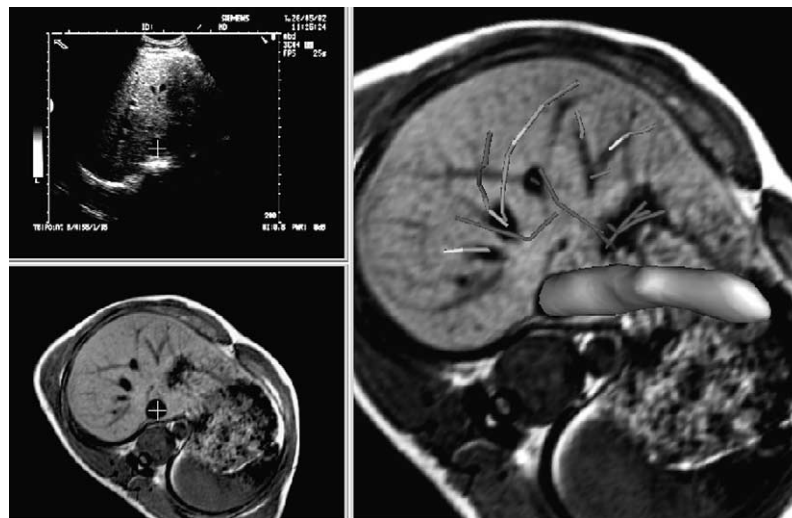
Graphical user interface used to pick points and lines to calculate “bronze standard” transformation. Top left shows an ultrasound slice in which vessel points are picked, bottom left shows the current best estimate for the corresponding slice through the MR volume. Right shows the 3D image features which have already been picked and the current best estimate for the MR slice. 3D line features can be manually picked in this window.
